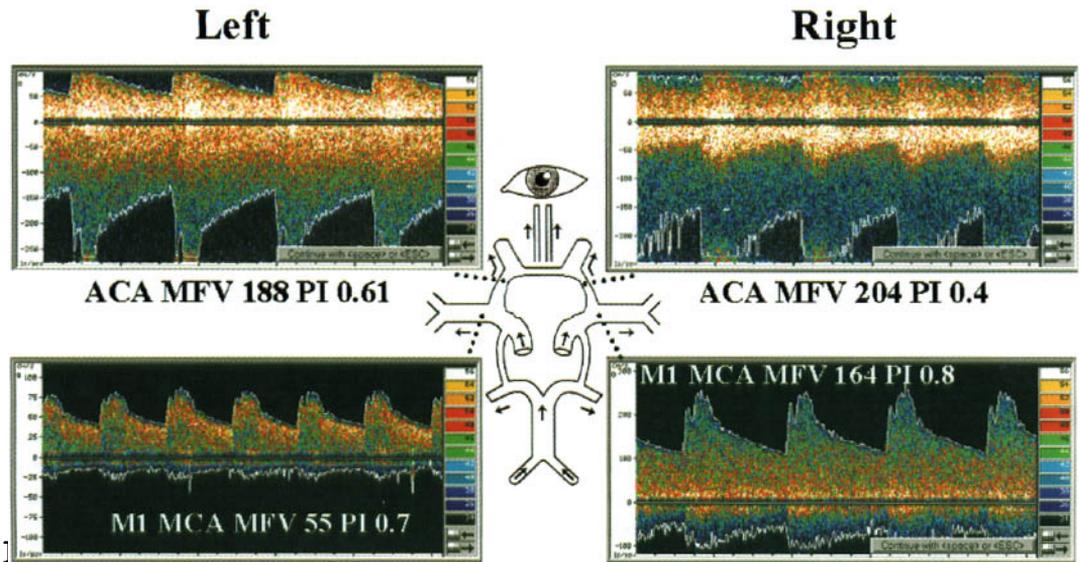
Transcranial Doppler findings in a patient with bilateral anterior cerebral artery vasospasm.
